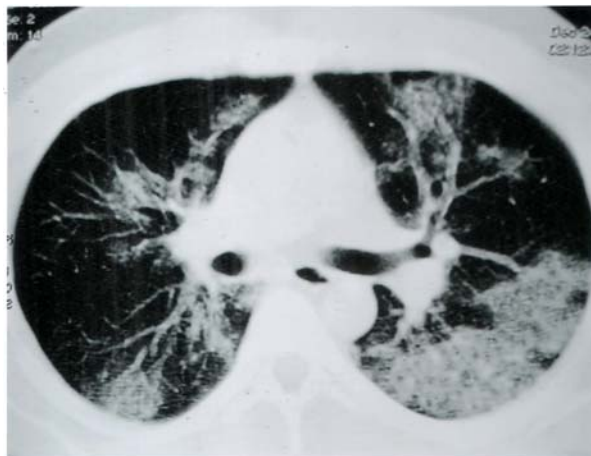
Lung window of CT thorax showing bilateral multi-focal patchy, rounded consolidation.
